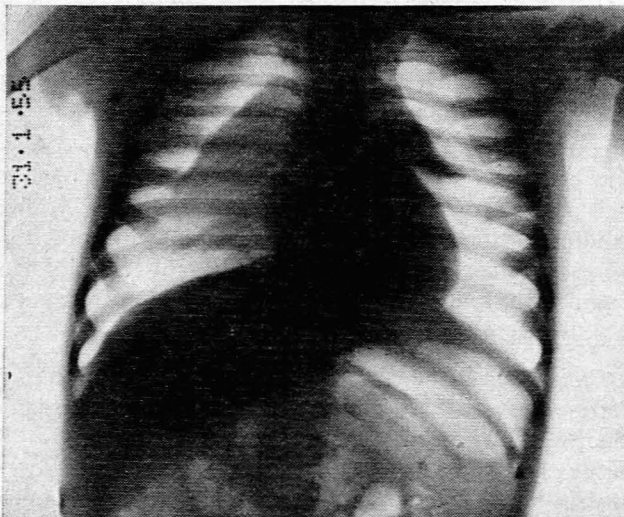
X-ray showing considerable bilateral pneumothorax. Note bulging of right auricle due to interference with pulmonary circulation.
